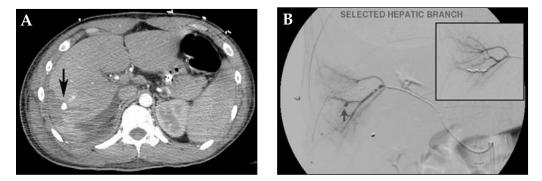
A small hepatic artery pseudoaneurysm after blast wound to the abdomen was noted at CT (A). In the operating room, a guiding catheter (RDC, Cordis, Miami Lakes, FL) was positioned at the SMA orifice and an angled glidewire/angled glidecatheter combination was advanced into a replaced right hepatic artery. A 3 Fr coaxial microcatheter system (Progreat, Terumo) with a .014" hydrophilic wire (PT2, Boston Scientific, Natick, MA) was then negotiated through the subsegmental hepatic arterial braches and out to the lesion (B) where coils were placed (inset).
